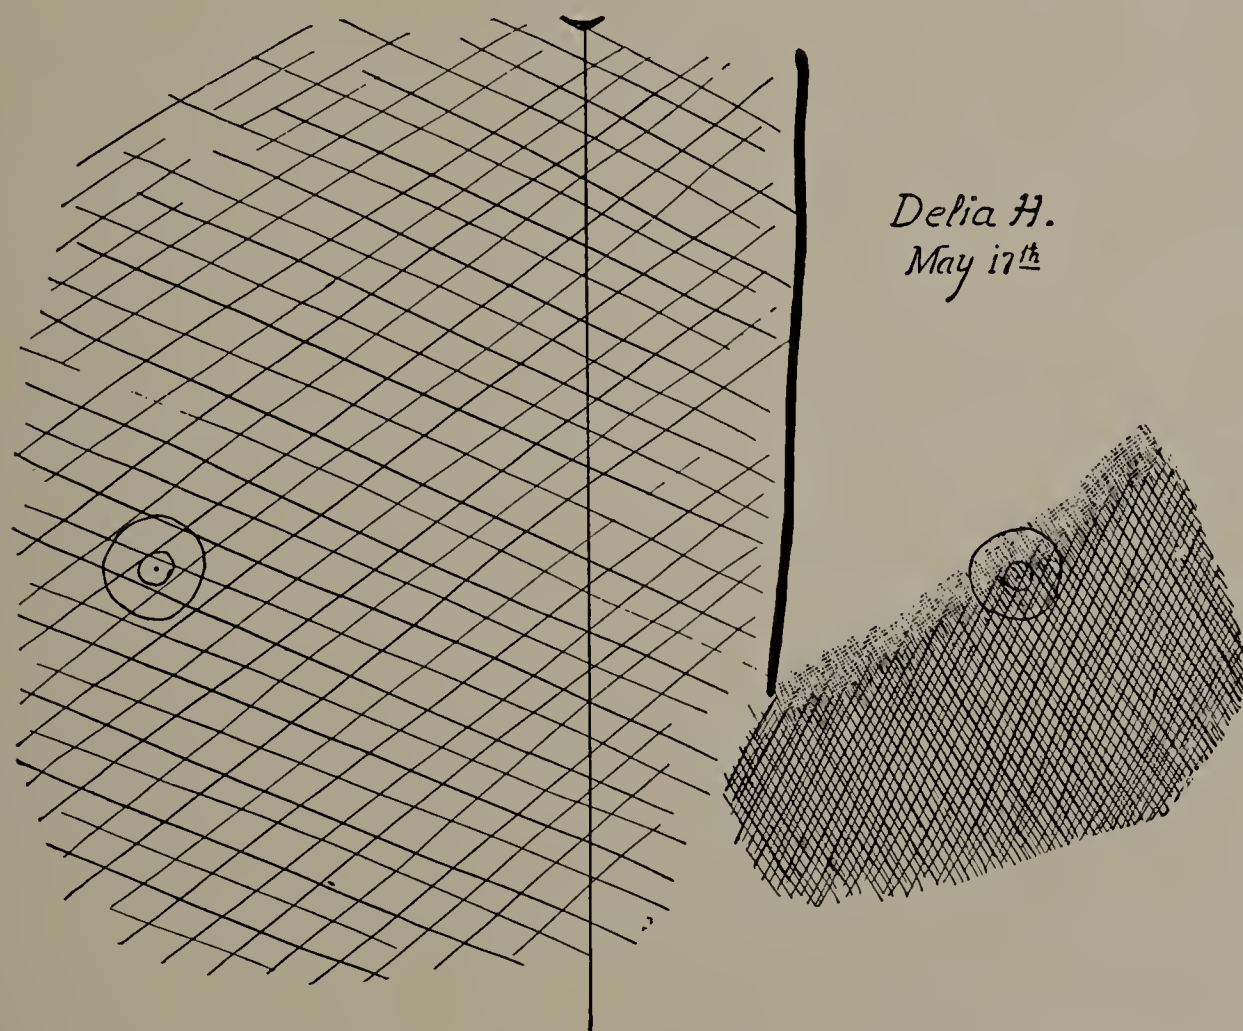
Delia H. May '17. Fourth X-ray tracing. Right thorax dark from tuberculosis. Left chest dark from pleurisy with effusion. (One-third life size.)
